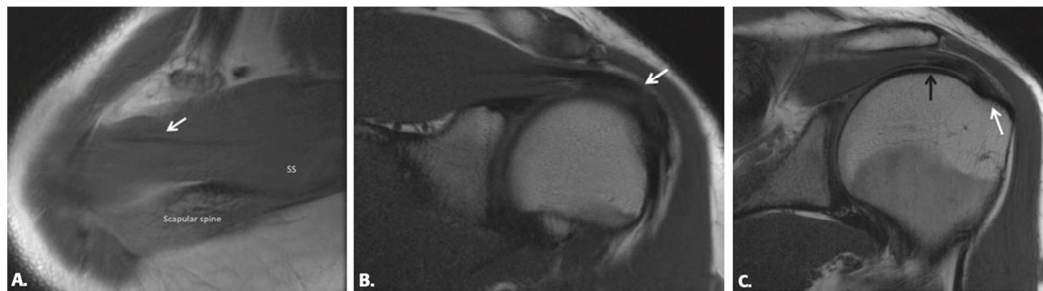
T1-weighted MRI pictures of the normal supraspinatus muscle and tendon (SS).
